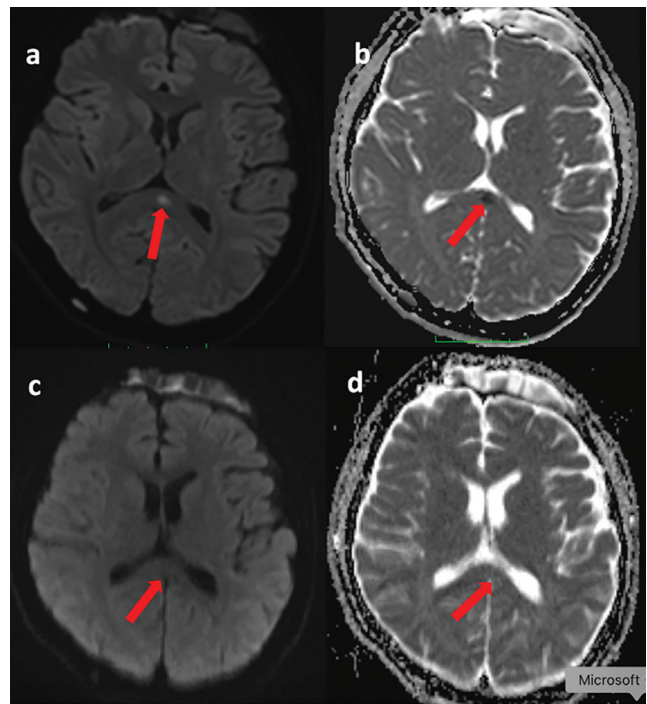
Fourteen-year-old male with pansinusitis and transient splenic lesion of the corpus callosum. Diffusion-weighted MRI obtained on admission (a, b) demonstrates a well-defined focus of restricted diffusion in the splenium of the corpus callosum (red arrow), without corresponding contrast enhancement, consistent with a transient cytotoxic lesion. Follow-up MRI performed 16 days later (c, d) shows complete resolution of the diffusion abnormality, confirming its reversible nature. This transient splenic lesion likely represents a secondary inflammatory or metabolic response associated with systemic infection and sinusitis, rather than direct infectious involvement of the corpus callosum
